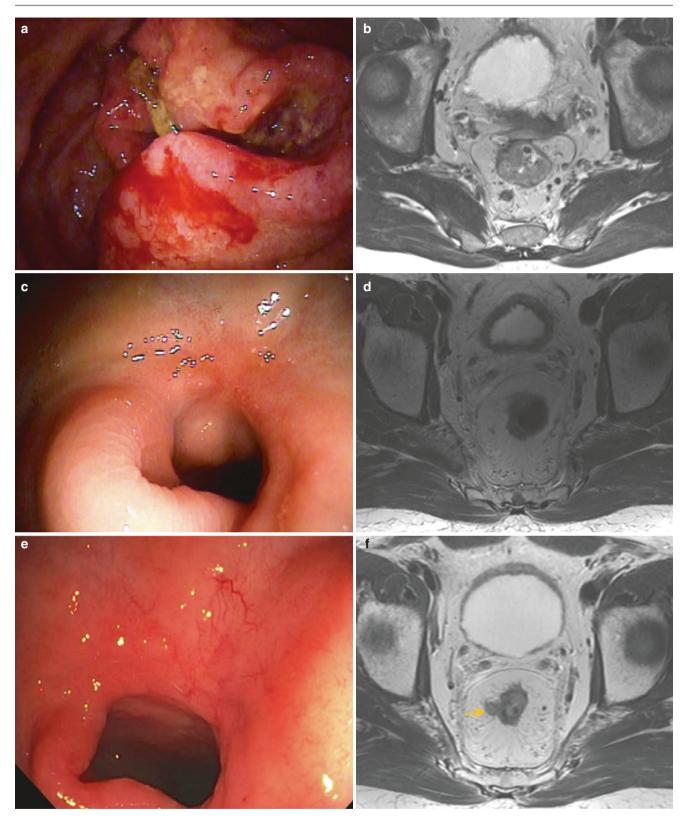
Tumor regrowth in the mesorectum. Paired endoscopic (a, c, e) and axial T2 MRI (b, d, f) images of a patient with rectal cancer at baseline (a, b), 14 weeks after completion of total neoadjuvant therapy
